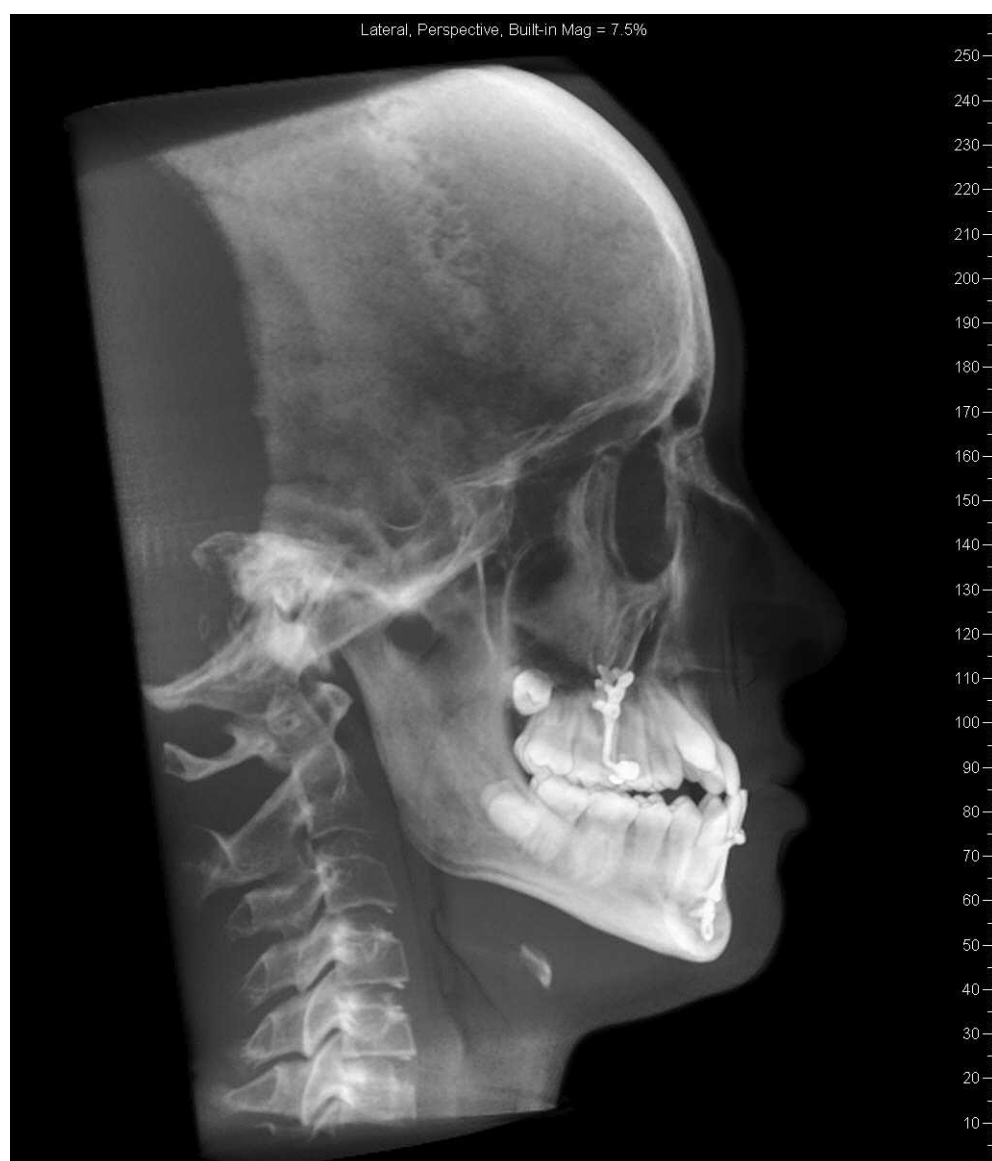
Synthetic lateral cephalogram generated from cone-beam computed tomography (CBCT).
